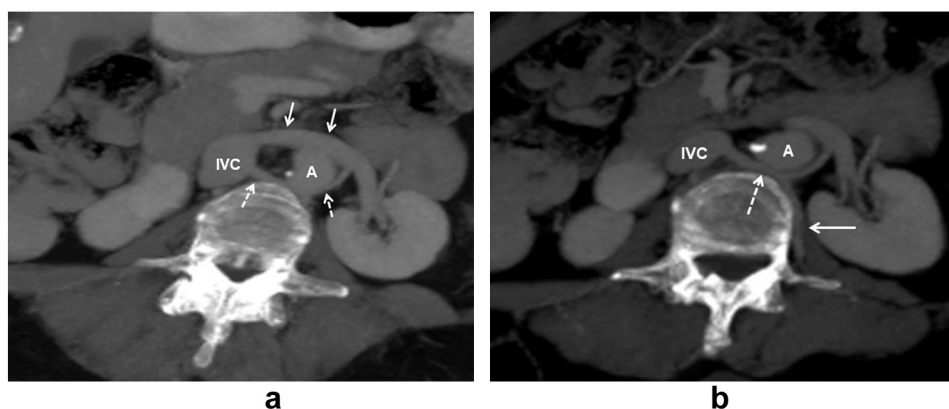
Normal anatomy of the ALCV in a 68-year-old female patient with circumaortic LRV. (a) Axial plane contrast-enhanced MIP CT image shows ventral (solid arrows) and dorsal limbs (dashed arrows) of the circumaortic LRV. (b) Note the ALCV (solid arrow) related to the dorsal limb of the circumaortic LRV (dashed arrow). A: Abdominal aorta IVC: Inferior vena cava.
